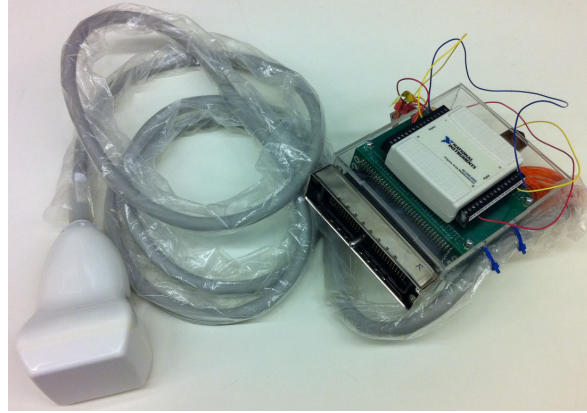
The 3D ultrasound transducer and our interface board.
